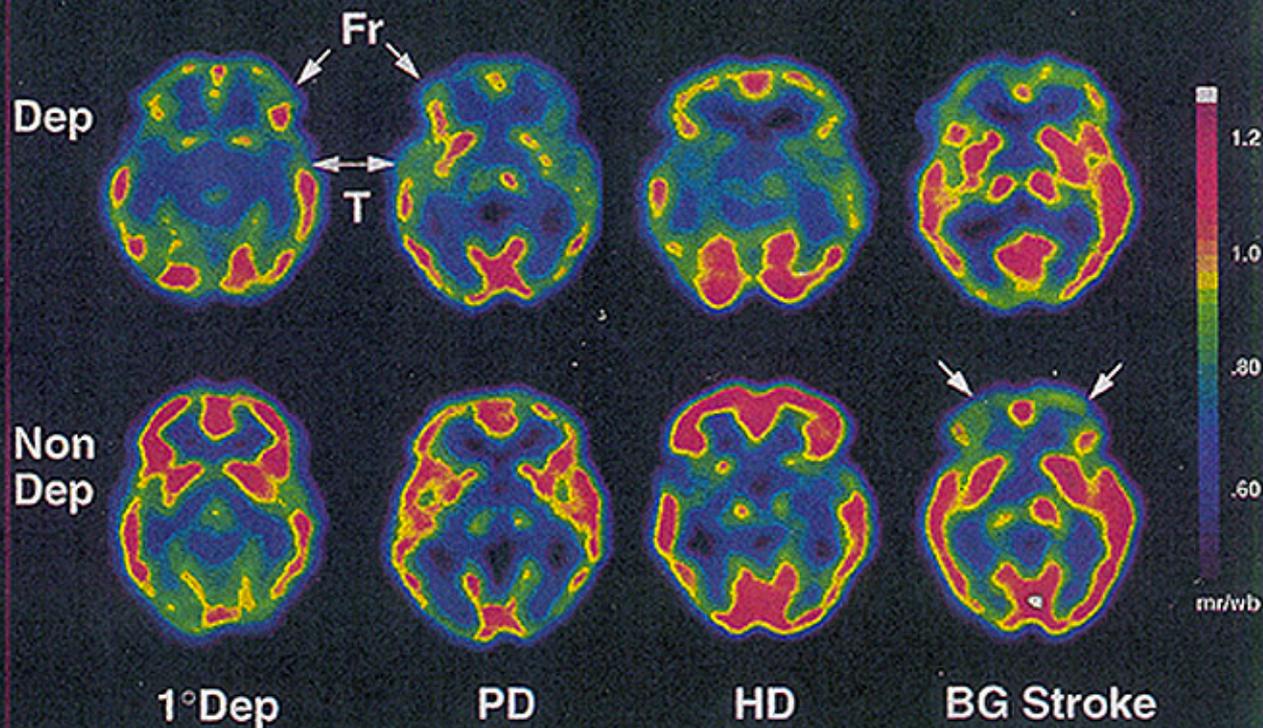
FDG-PET images in patients with primary and secondary depression. Symmetric, bilateral ventral frontal and anterior temporal hypometabolism is seen in depressed patients (Dep), independent of disease etiology (arrows, top row). Cortical metabolism is normal in nondepressed patients (Non Dep), except for the frontal cortex in patients with caudate strokes (arrows, bottom row). Scale is relative metabolic rate for glucose (region/whole brain). Abbreviations: Fr = frontal; T = temporal; 1°Dep = primary depressive disorder; PD = Parkinson's disease; HD = Huntington's disease; BG = basal ganglia; mr = metabolic rate; wb = whole brain.
